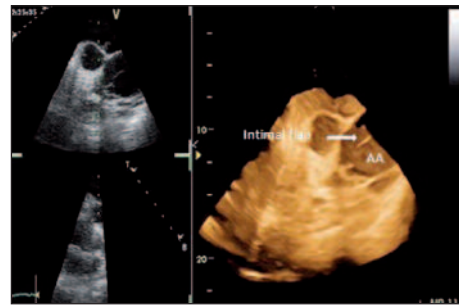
Modified parasternal long axis view of real time three dimensional transthoracic echocardiography demonstrating intimal dissection flap.
